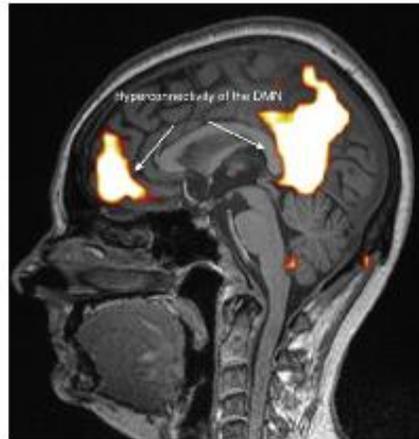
Abnormal functional MRI brain scan in patients complaining of EHS after long-term exposure to EMF, according to Reference [31].
